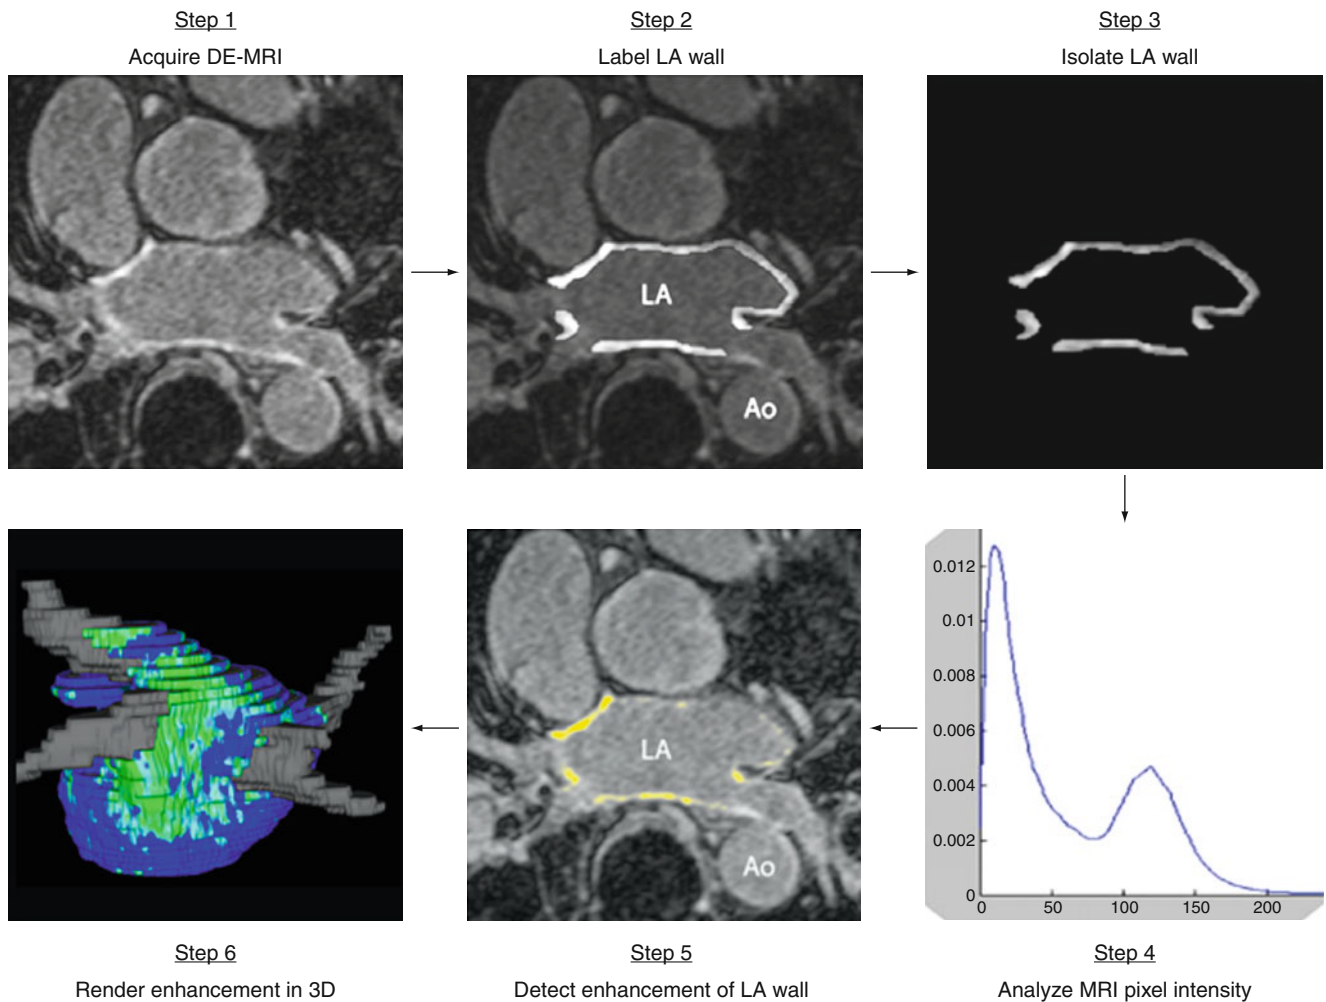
LGE-MRI quantification of pre-ablation fibrosis/structural remodeling and postablation scarring. After LGE-MR images are obtained (1), the endocardial and epicardial borders are manually contoured and isolated (2, 3), and the extent of LGE is then quantified using a pixel intensity distribution (4), qualitative confirmation is then
